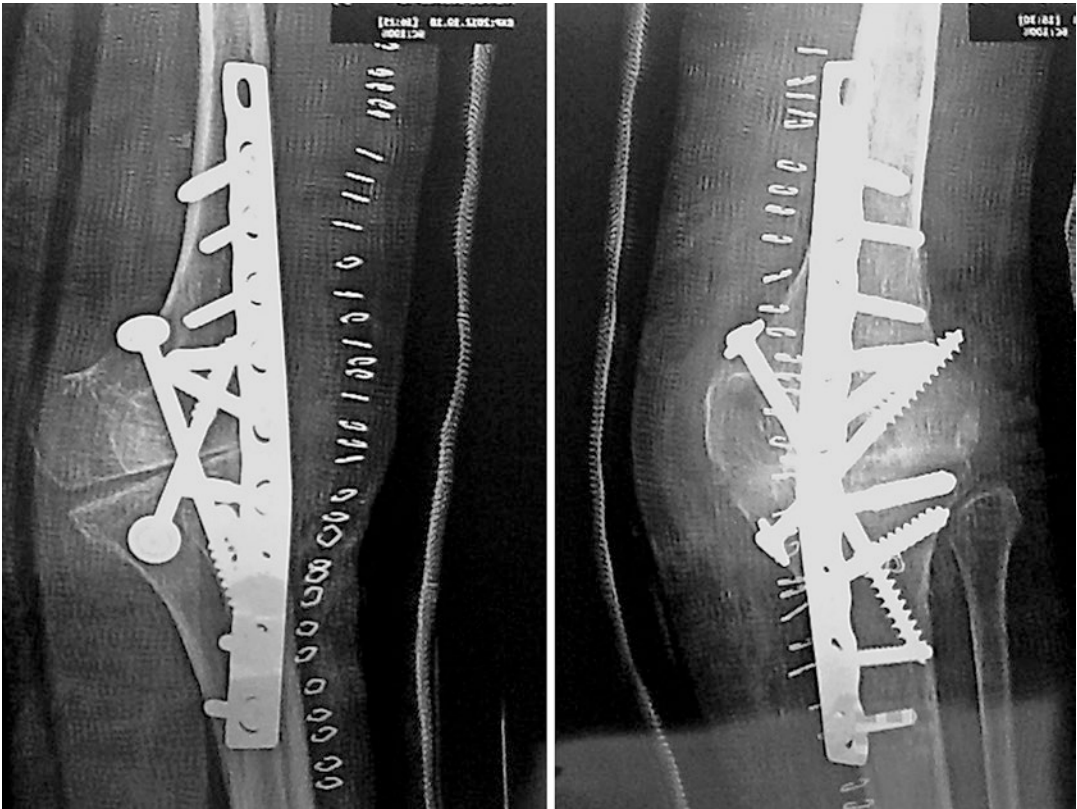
Post-op X-rays of knee fusion with compression screws and anterior neutralization plate. The alignment is good in the frontal plane, but there is some recurvatum in the sagittal plane, not the desired 5° of flexion. This 62-year-old woman had polio in both legs as a
